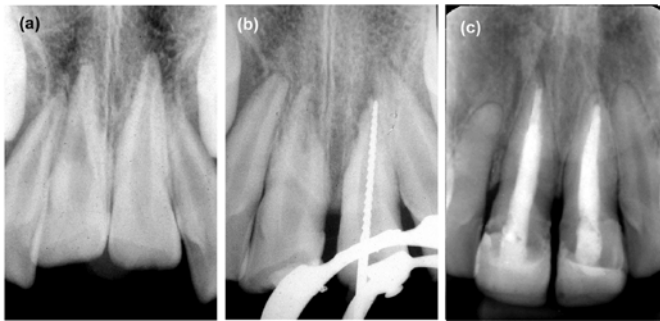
Radiographic images; A) Periapical radiograph showing severe intrusion of teeth 11 and 21, with completely formed roots and closed apical foramen; B) Odontometry of tooth 11 during endodontic treatment; C) 10-year radiographic control, showing the integrity of the periodontal ligament and minor horizontal loss of the alveolar bone
